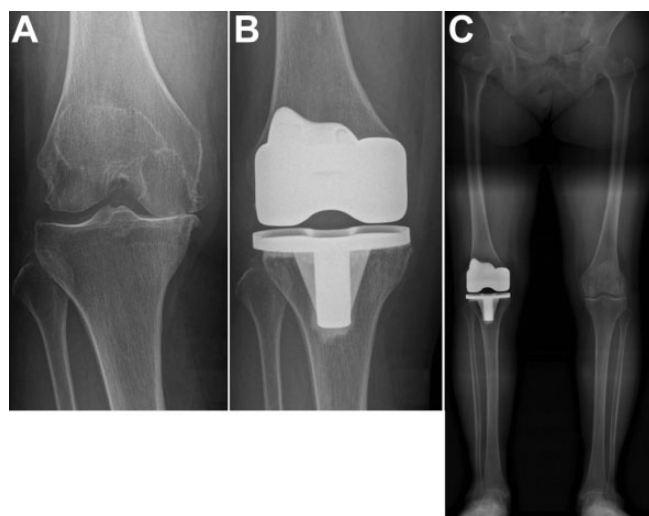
(A) Preoperative radiograph showing advanced osteoarthritis in a right knee. (B) Knee and (C) standing long-leg radiographs after total knee replacement.
